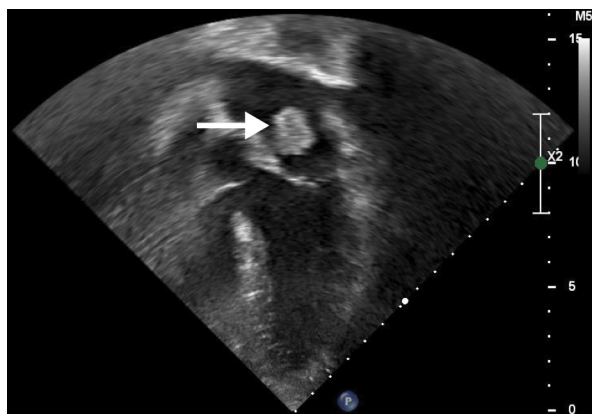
Two-dimensional echocardiography (2DE), five-chamber projection. A 1.3×1.5 cm tumour is present in the left atrium, just above the mitral valve (arrow). It did not impede blood flow through the mitral valve during heart movement
